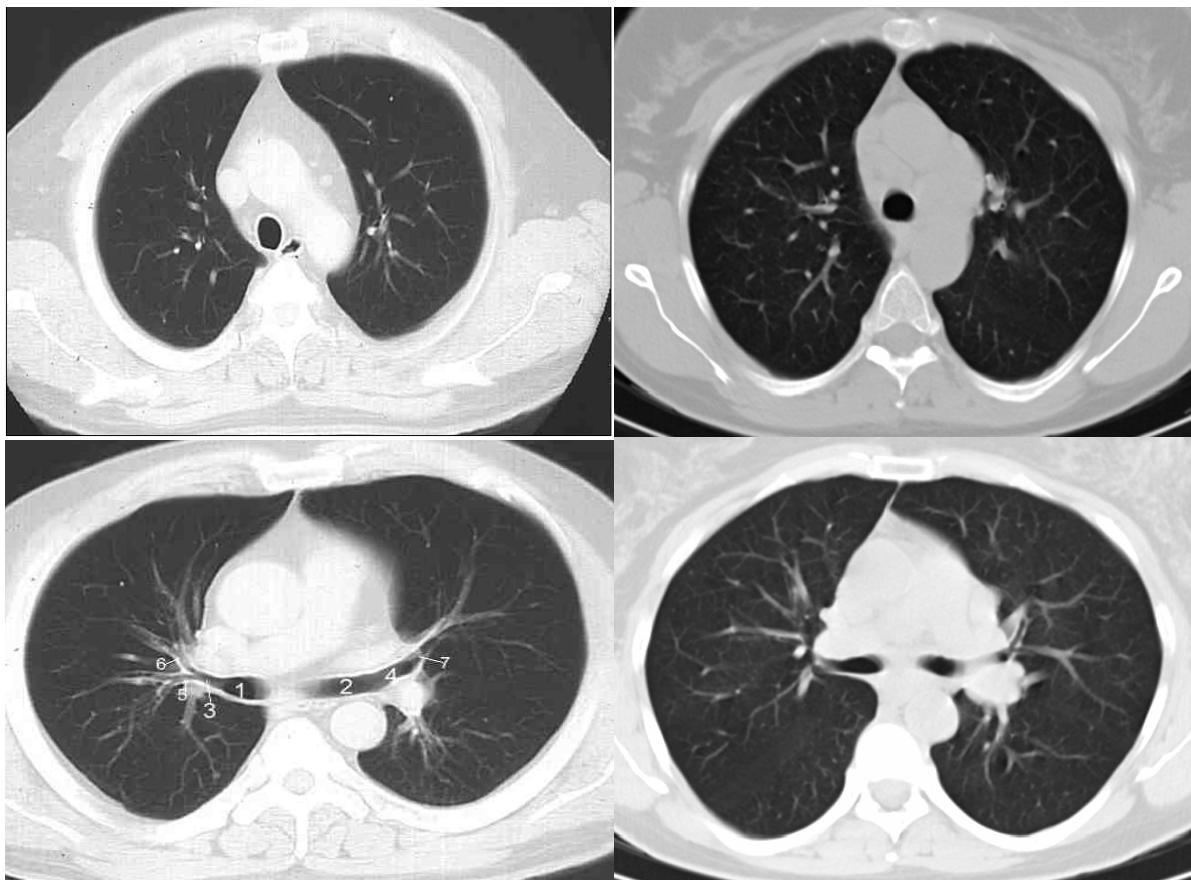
CT of the lungs. Normal CT of the lungs. Sarcoidosis, Stage I (intrathoracic lymphadenopathy).
